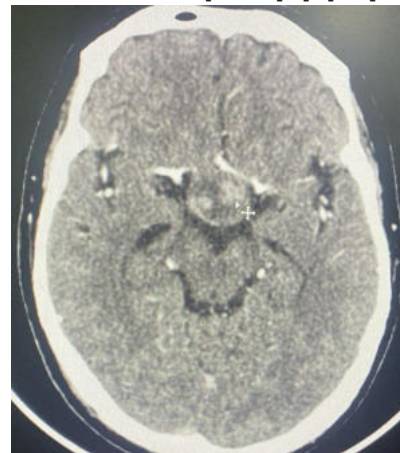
A Computed Tomography (CT) Axial image showing a well defined hypodense lesion suggestive of pituitary adenoma with multiple hyperdense areas suggestive of haemorrhages as shown by the arrowhead.
